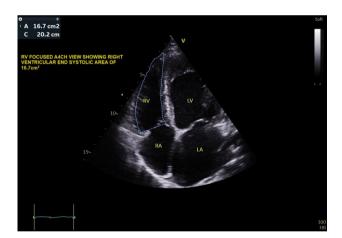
Echocardiographic still image of one of the participants showing determination of the RVESA (16.7 cm²) in the apical four chamber view used to determine the RVFAC. RVEDA, right ventricular end diastolic area; RVFAC, right ventricular fractional area change; RV, right ventricle; RA, right atrium; LA, left atrium; LV, left ventricle; HR, heart rate.
